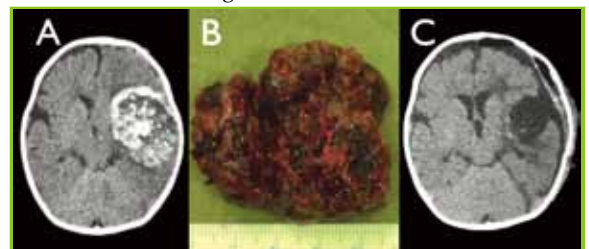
Cavernoma presented as a vascular tumour in a boy of 7 months old. A. Preoperative CT B. The excised lesion C. Postoperative CT.
